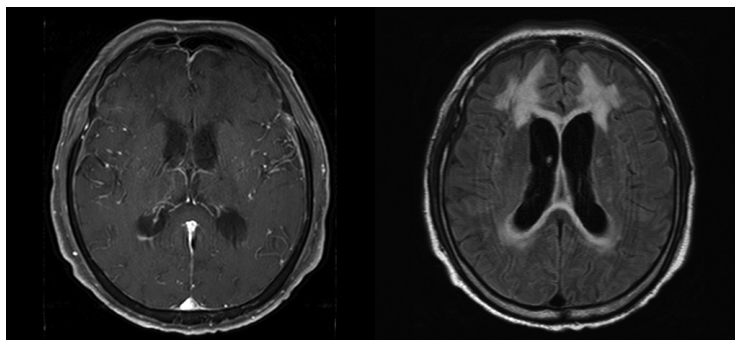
The follow-up brain MRI of the patient in 2 months. Axial T1-weighted gadolinium-enhance and FLAIR images showed slightly more progressed hydrocephalus with increased white matter change especially in anterior portion compared with posterior portion.
